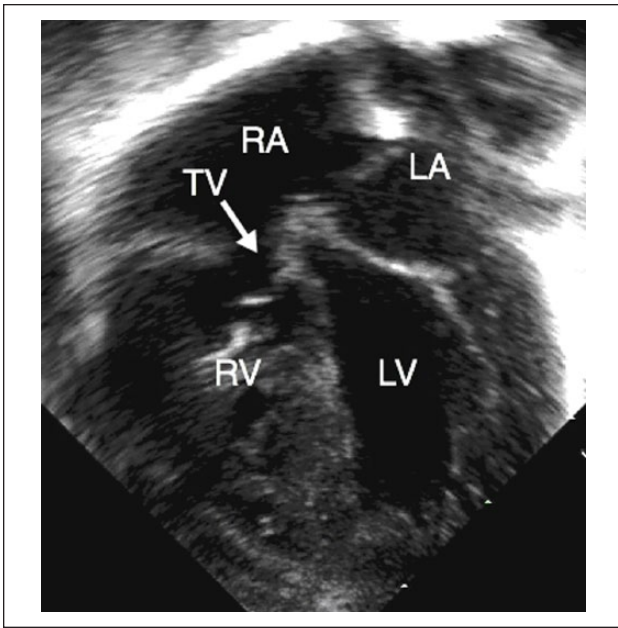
Apical 4-chamber echocardiographic view in an infant with pulmonary atresia and intact ventricular septum demonstrates a severely hypoplastic tricuspid valve (TV) and right ventricle (RV) with severe RV hypertrophy. LA, left atrium; LV, left ventricle; RA, right atrium.
